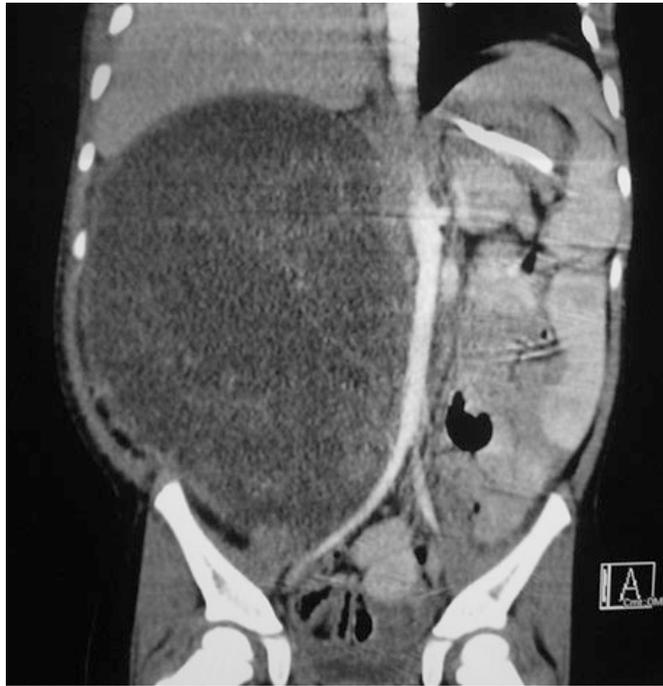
Abdominal CT from same boy showing important mass with no renal tissue observed: diagnosis of Right PUJ obstruction
